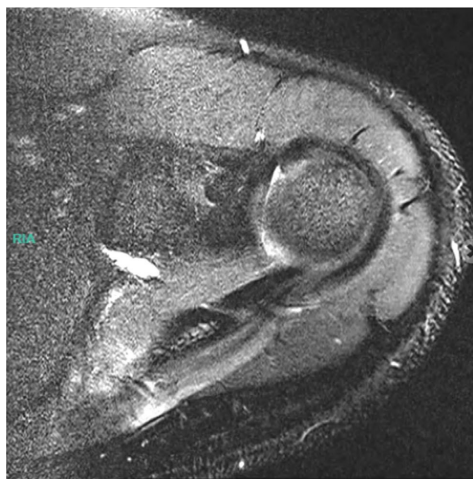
Transverse view of MRI showing left suprascapular nerve enhancement as it crosses the supraspinatus.
